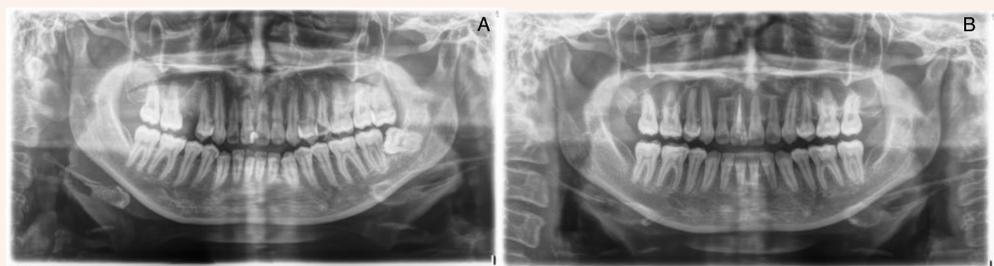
Pre- and post panoramic radiographs. (A: Pre-treatment; B: Post-treatment)
